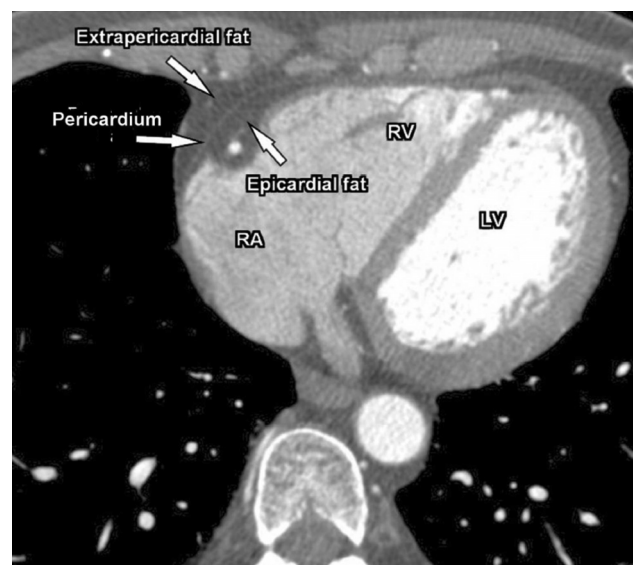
Axial computed tomography (CT) image defining the intrathoracic fat compartments. The pericardium (white arrow) divides the intrathoracic fat into epicardial and extrapericardial fat (arrows).
